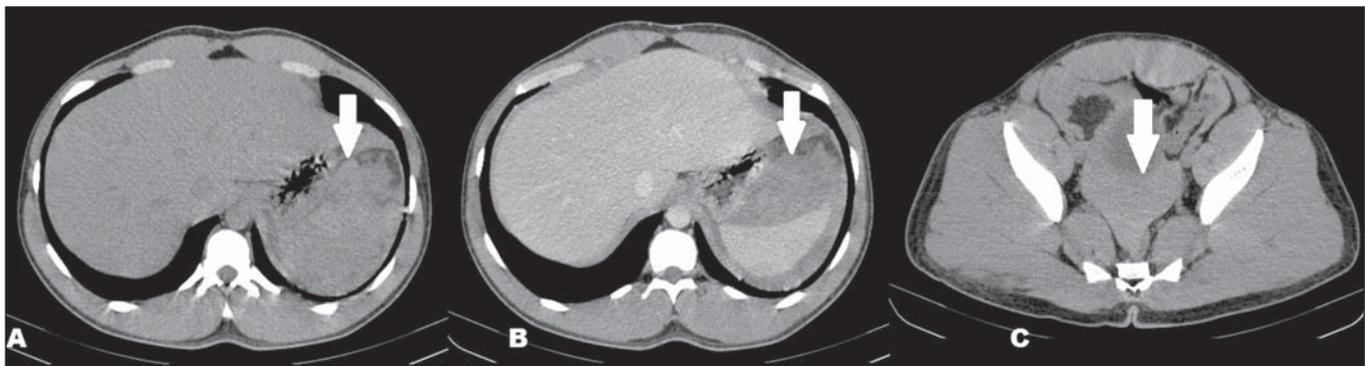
CT scan showing subcapsular hematoma and hemoperitoneum. A: CT, axial slice, without contrast, demonstrating dense collections (arrow) adjacent to the spleen. B: Contrast-enhanced axial CT, showing the dense collections adjacent to the spleen (arrow), without contrast enhancement, indicative of subcapsular hematoma. C: CT, axial slice, without contrast, demonstrating spontaneously dense free liquid in the pelvis (arrow), indicative of hemoperitoneum.
